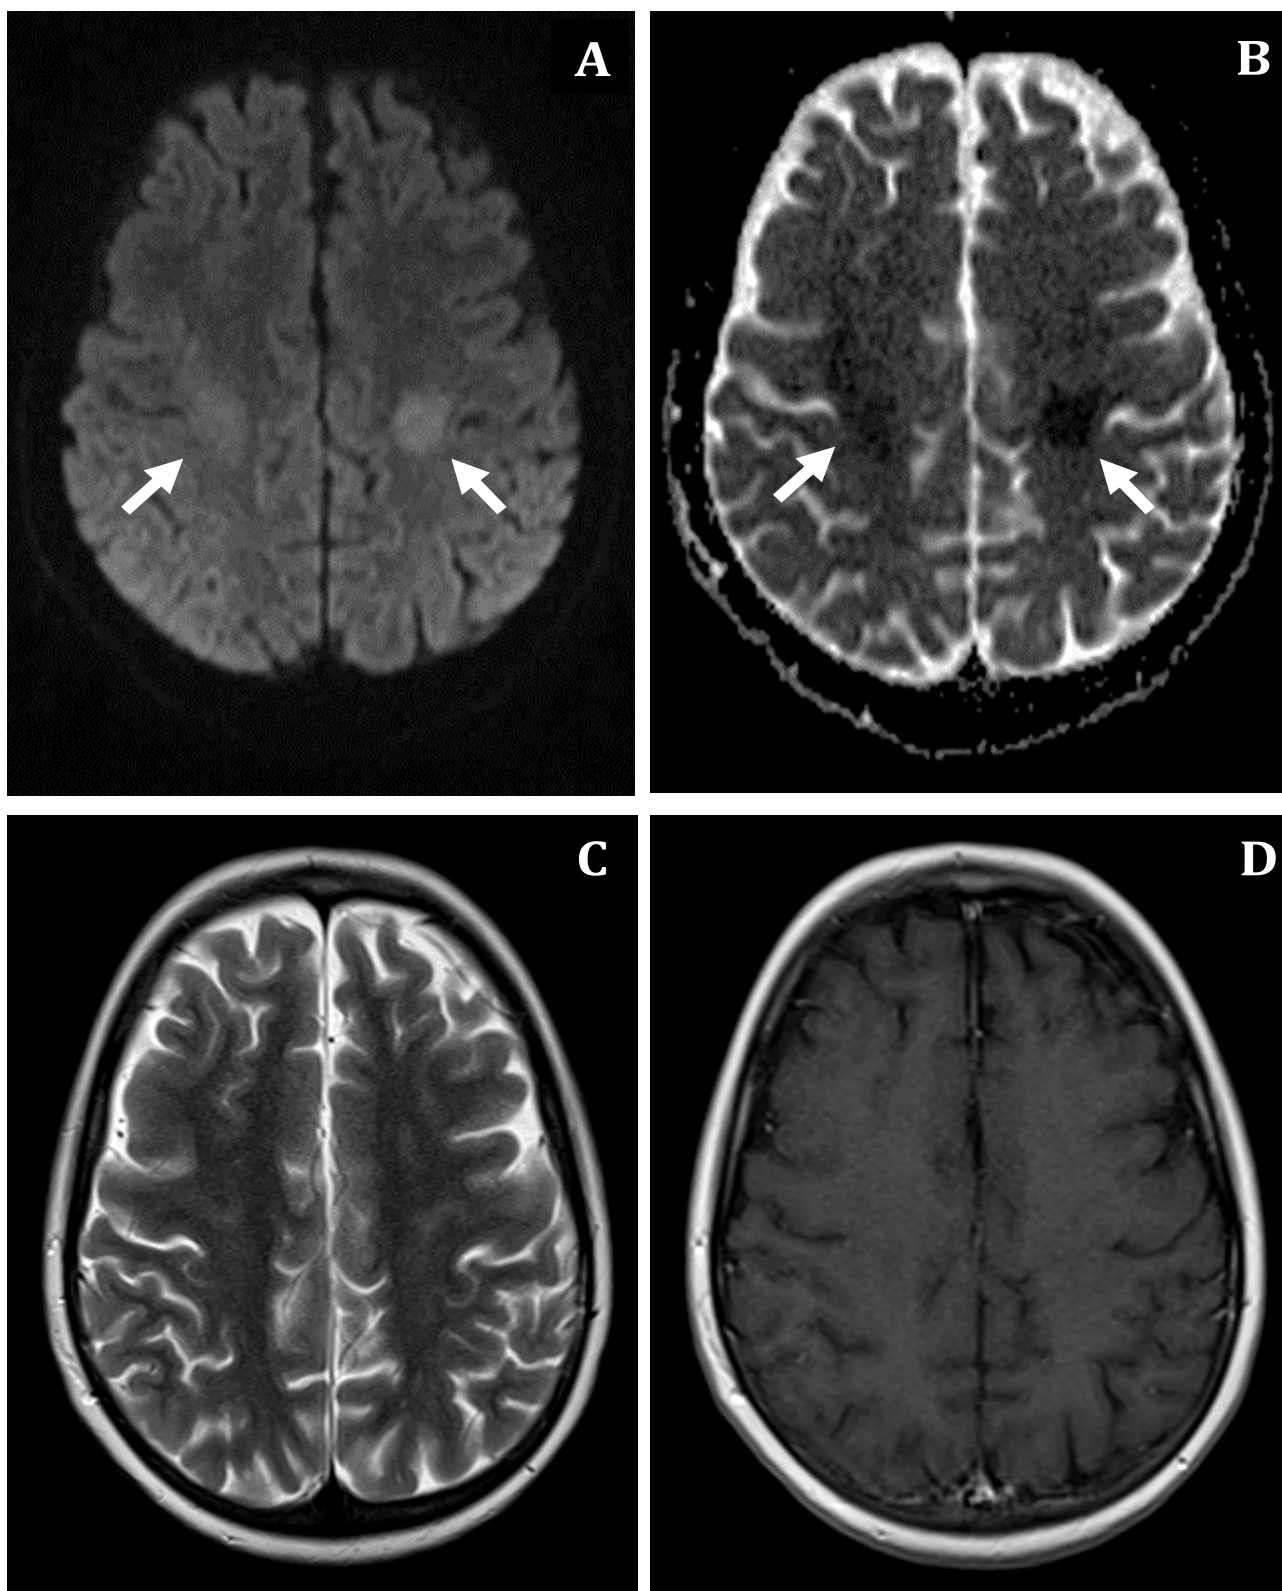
MRI at the symptomatic period. A: Axial diffusion image ( $b=1000$  s/mm<sup>2</sup>) demonstrates high signal intensity in bilateral centrum semiovale (more prominent on the left, arrows), B: Corresponding ADC map reveals low values at affected sites showing the diffusion restriction (arrows), C: T2 weighted (TR/TE: 5390/106 ms) reveals no apparent signal abnormality corresponding to the areas with restricted diffusion, D: Postcontrast T1 weighted image (TR/TE: 590/14ms) shows no abnormal contrast enhancement in the affected areas.
